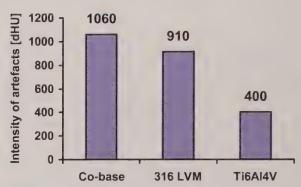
Intensity of artefacts during CT scanning
